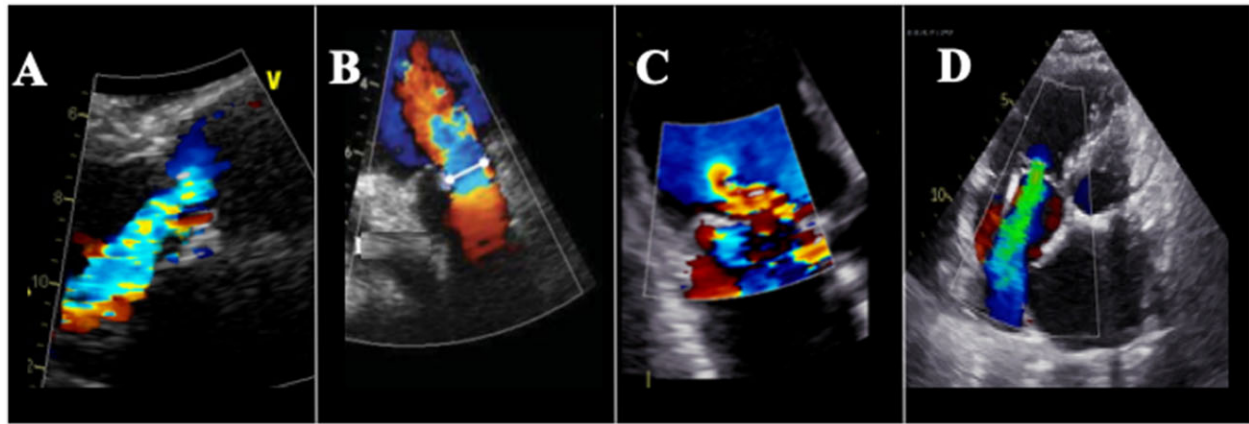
Assessment of the regurgitant jet by colour flow Doppler (A: aortic; B: pulmonary; C: mitral; D: tricuspid).
